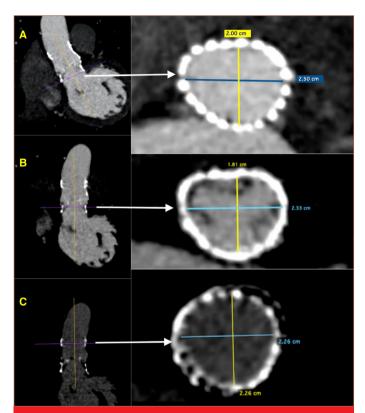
Computed tomography of the degenerated PER-CEVALTM valve and annulus measurements from (a) basal level, (b) 5 mm above basal level, and (c) ascending aorta level
